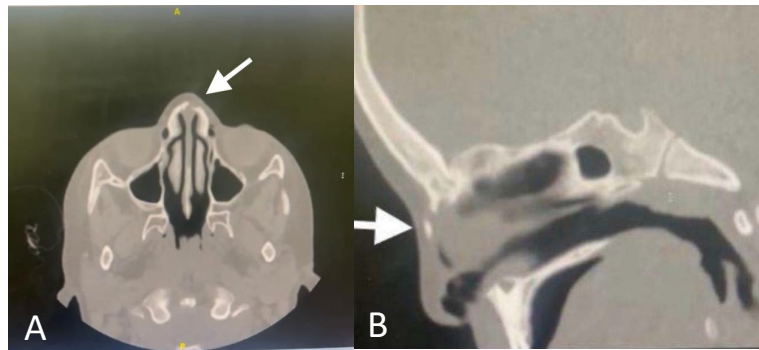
CT scan axial cut (A) and sagittal (B), showing a nasal bone defect.
